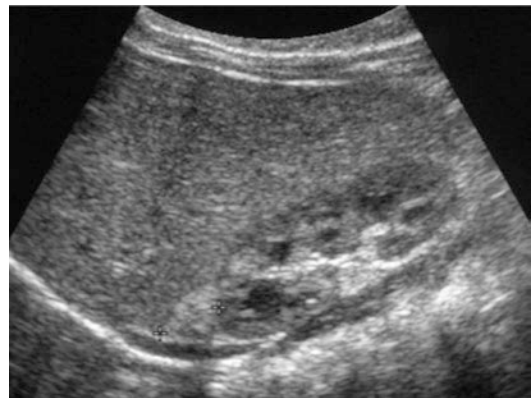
Ultrasound exam shows an acute stage adrenal hematoma: the adrenal gland is hyperechoic (calipers), it maintains its triangular shape and the cleavage with the upper pole of the kidney
